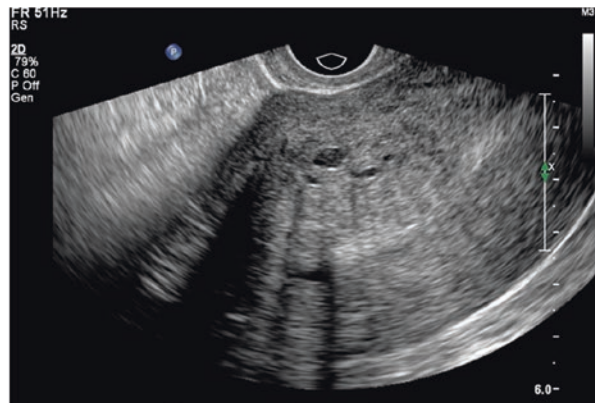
(a and b) Transabdominal ultrasound images of diffuse adenomyosis, the uterus is anteverted, which shows that the anterior uterine muscle layer is significantly thickened, and the echo is heterogeneous. Multiple small anechoic areas scattered in the lesion are visible. (c) TVUS image of adenomyosis. The uterus is anteverted. It shows that the anterior wall of the uterus is thickened, and the echo is uneven. Several small anechoic areas (pointed by arrows) are visible
